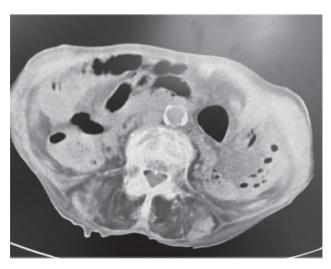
Abdominal computed tomography (CT) depicting intramural intestinal gas.
